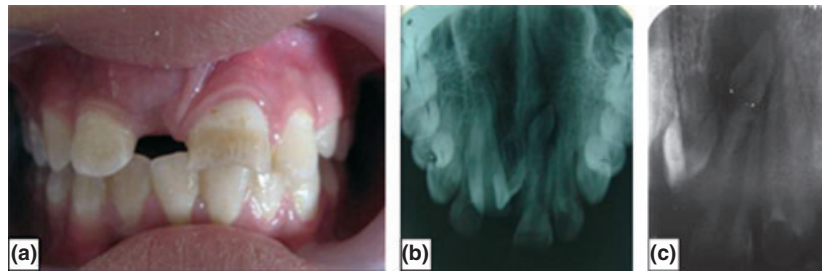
(a) Pretreatment intraoral photograph showing the non-eruption of maxillary right central incisor and fracture of clinical crown of the left incisor. (b) Pretreatment occlusal radiograph showing the impacted right central incisor and presence of two mesiodentes, normally oriented and the other inverted. (c) Pretreatment periapical radiograph showing a well-defined radiolucent area with radiopaque border surrounding the inverted mesiodens. Note the wide open apex of left central incisor.
